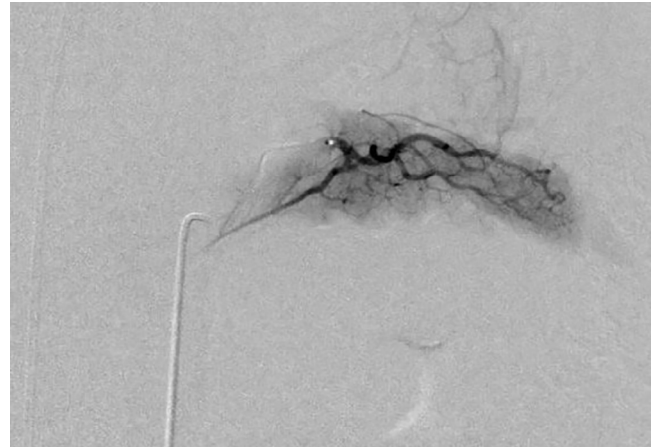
Digital subtraction angiogram of the pancreatic magna artery produced via contrast injection from a Renegade HI-FLO microcatheter coaxially introduced through a 5Fr C2 catheter demonstrates uniform pancreatic body and tail parenchymal enhancement without focal hypervascularity of the known pancreatic tail lesion detected on previous computed tomography and magnetic resonance imaging.
